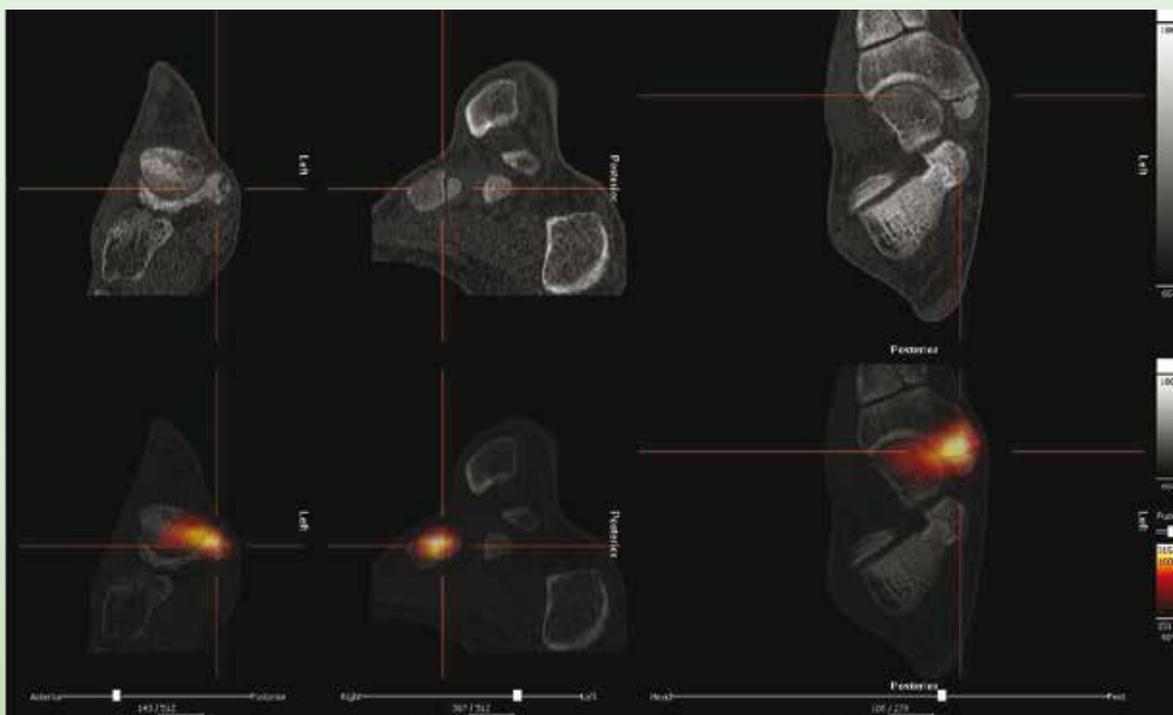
SPECT/CT of patient nr 3 showing locally increased uptake at the level and interface of the accessory navicular and navicular bone.
